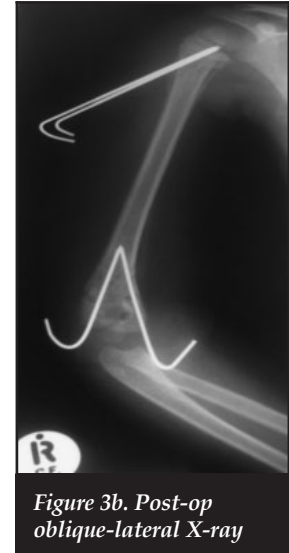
Post-op oblique-lateral X-ray
